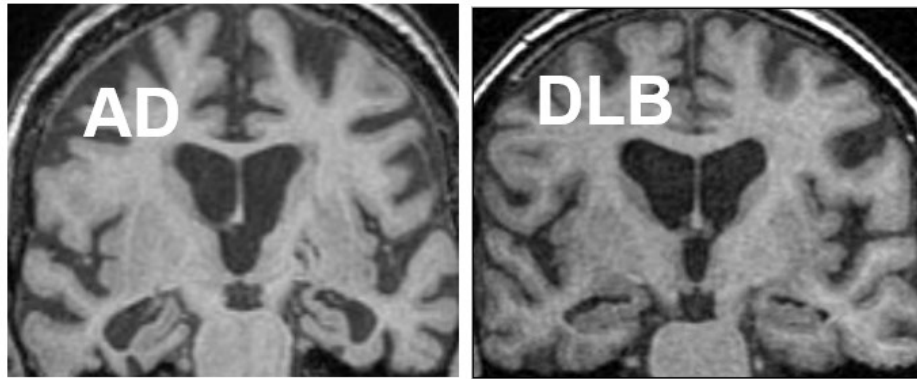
These coronal views of T-weighted MRI scans show comparison between a marked atrophy in the whole brain and especially in MTL in an AD patient (left) who is of the same age and same global cognitive status than DLB patient (right) with less pronounced atrophy and relatively spared MTL. Courtesy of Dr. Zuzana Nedelska
